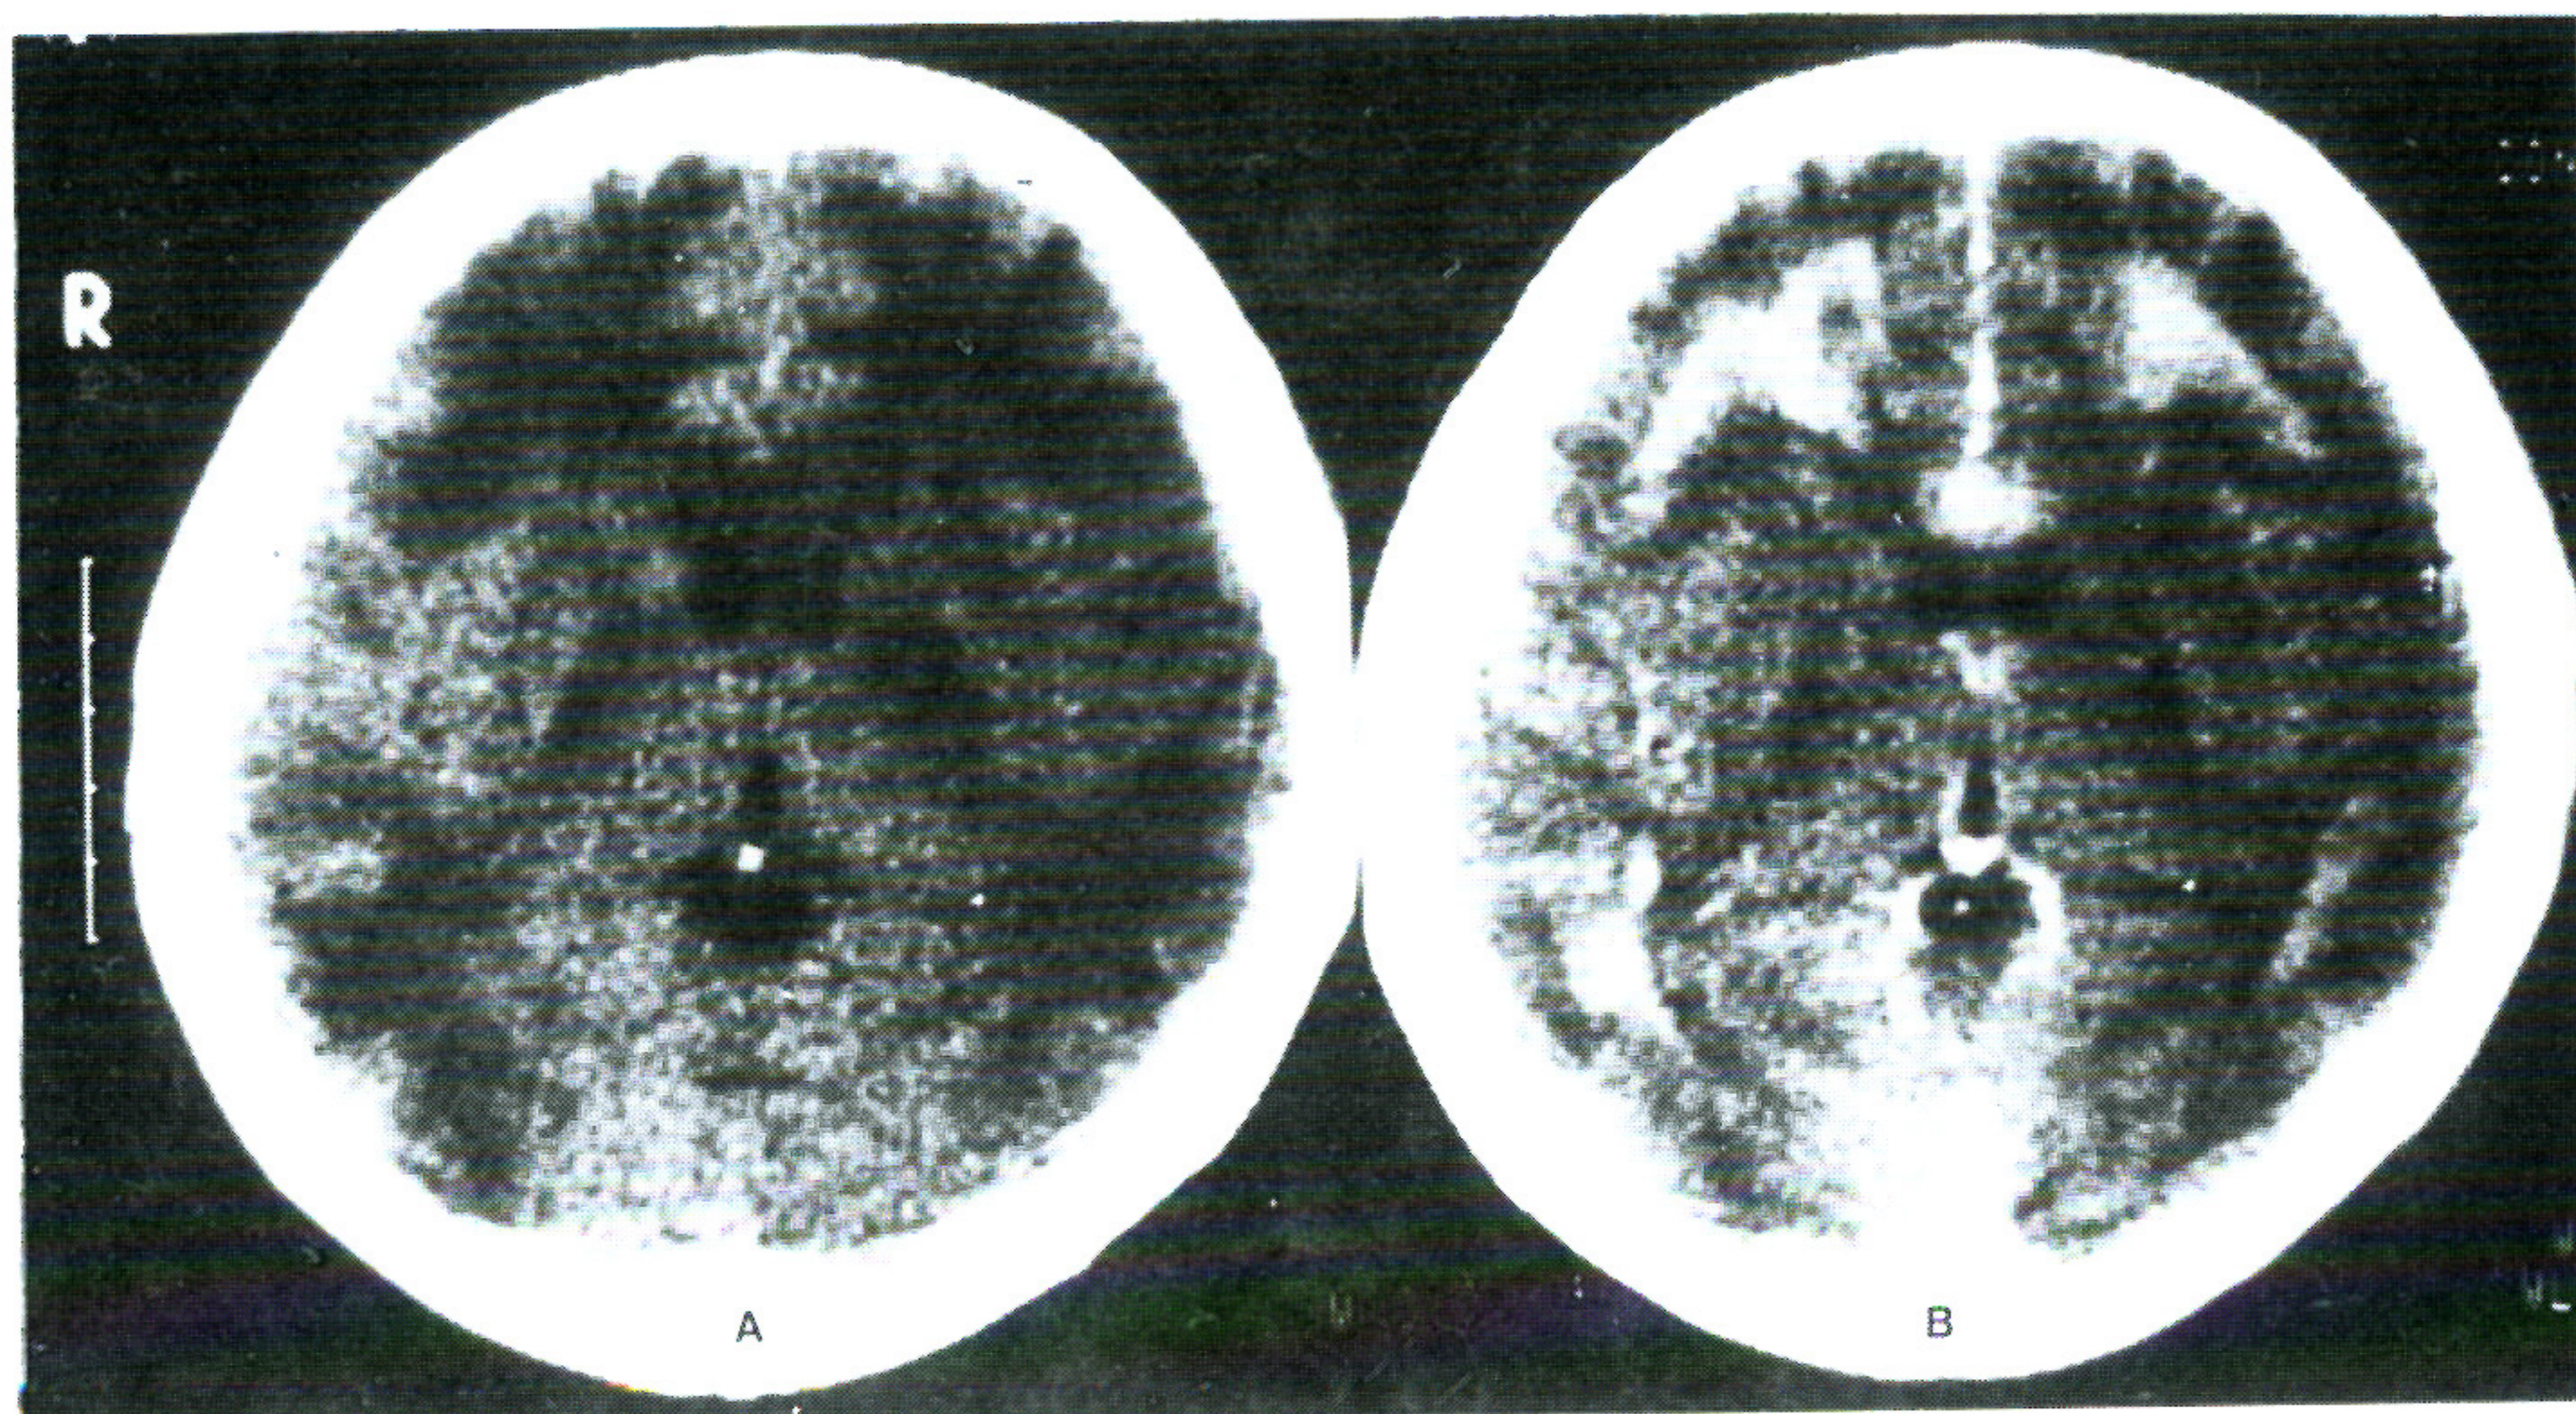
A. Pre-contrast CT scan 15 days after anoxia showed low-density in both globus pallidi and cerebral white matter. B. Post-contrast CT scan clearly demonstrated contrast enhancement in the areas of subcortical white matter, particularly the frontal areas.
